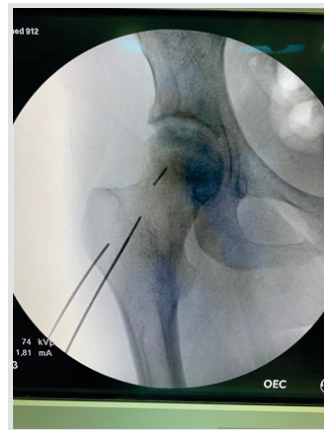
Radiographs at presentation broken K-wire in the neck of femur.
